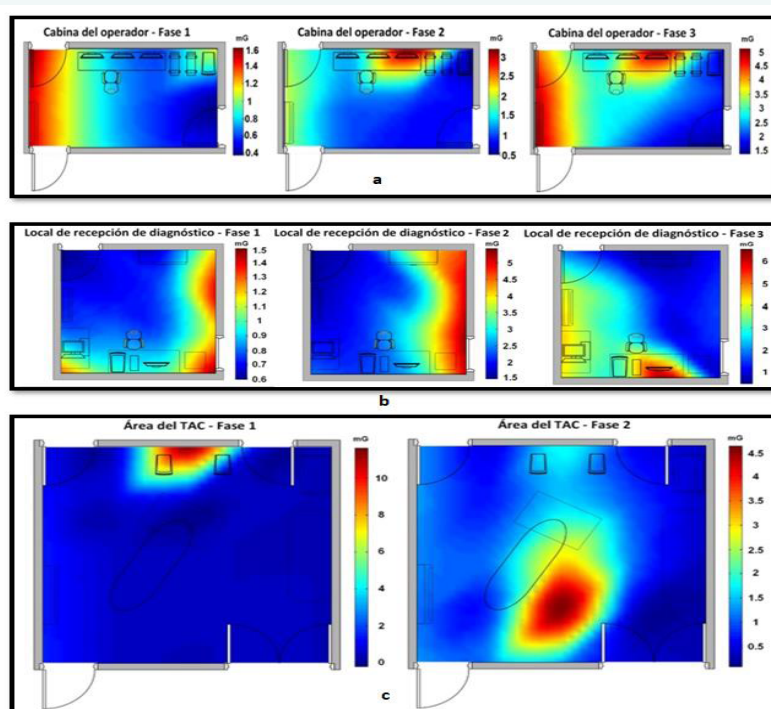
Graphic representation using colors of the average magnetic field values of a- operator's cabin, b- diagnostic reception area, c- CT area.
